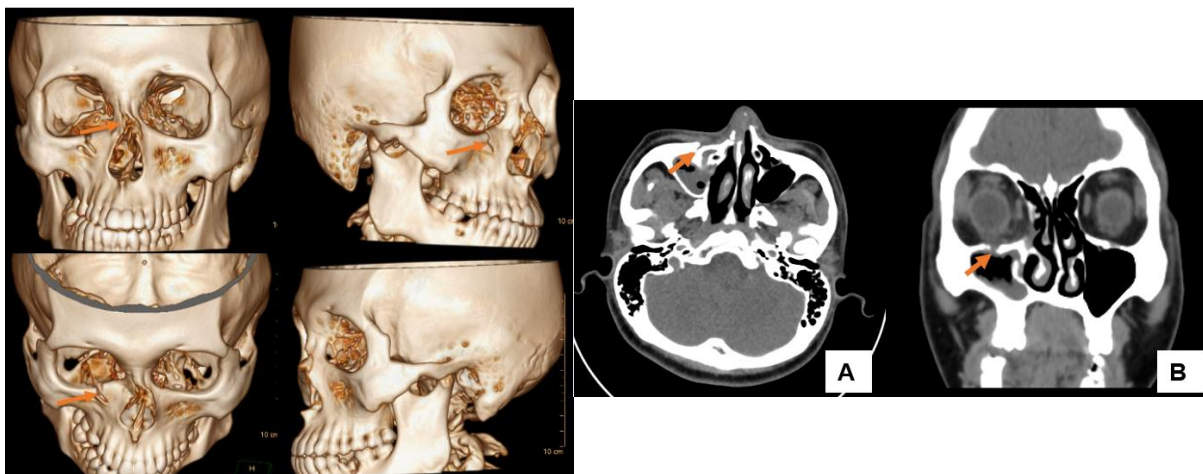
Orbital CT scan 3D orbital showing fracture of the floor of the right orbit (red arrow)
